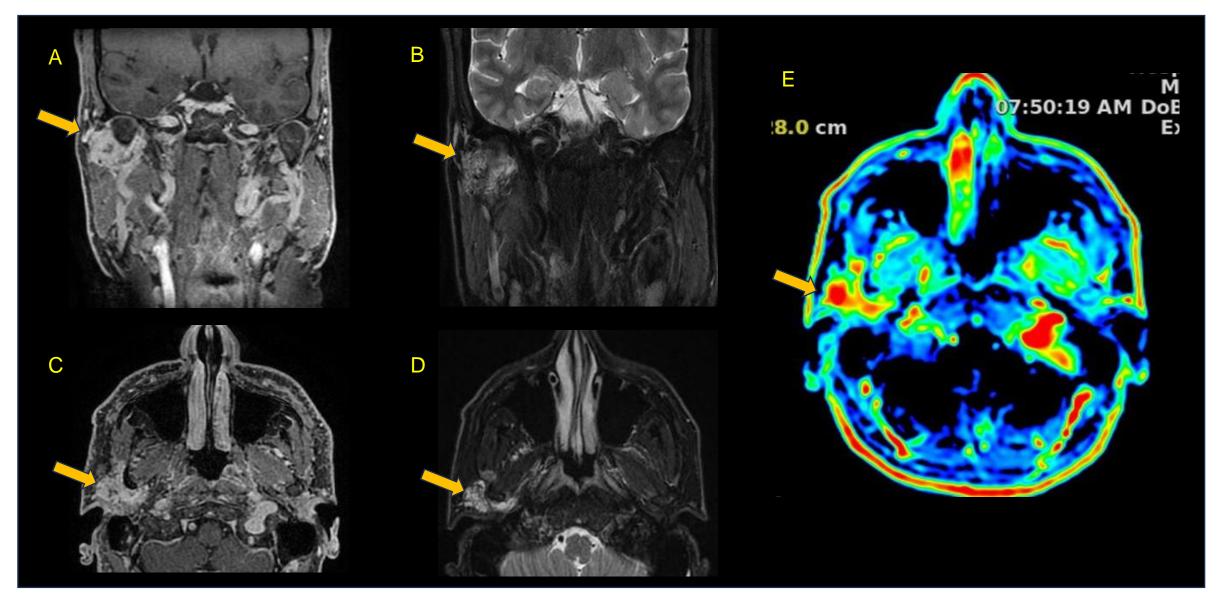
Parotid Venous Malformation. A: MRI, coronal T1. B: MRI, coronal T2 STIR. C: MRI, axial T1. D: MRI, axial T2 STIR. E: Permeability map. Yellow arrow: MRI shows lobulated nodular lesion in the upper third of the right parotid gland, involving the mandibular condylar process, without bone erosions, characterized by isosignal on T1, heterogeneous hypersignal on T2, and post-contrast enhancement, with increased perfusion on the color map.
